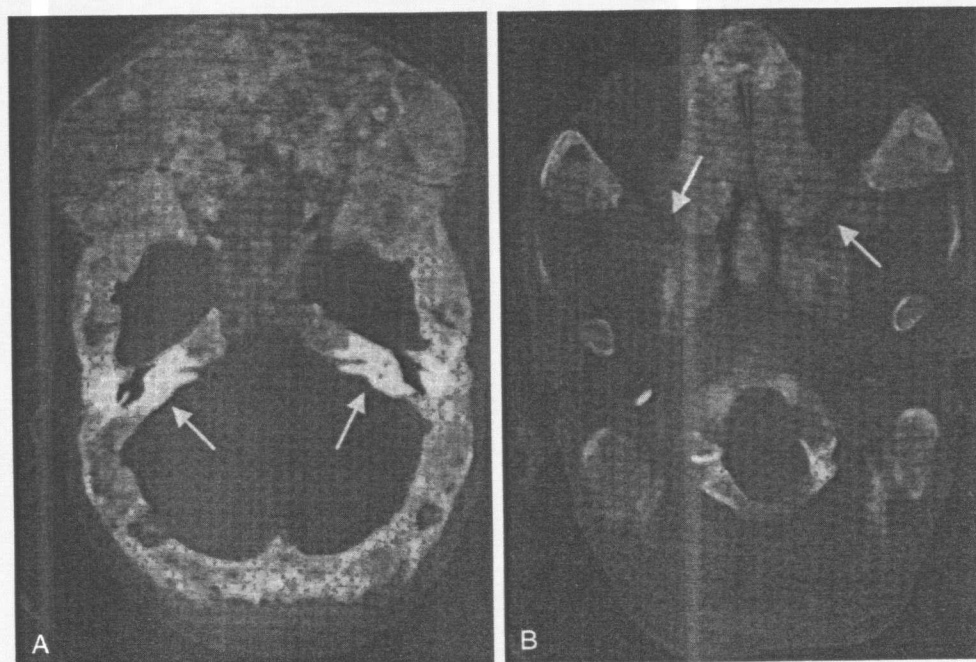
Vital structure sparing in massive craniofacial FD. Selected images of a computed tomographic scan of the skull of a patient with massive craniofacial FD are shown. Virtually every craniofacial bone but the petrous bone is involved. In spite of this degree of involvement, key vital structures are spared. A, Petrous ridge and auditory canal sparing (arrows). B, Optic nerve sparing (arrows).
